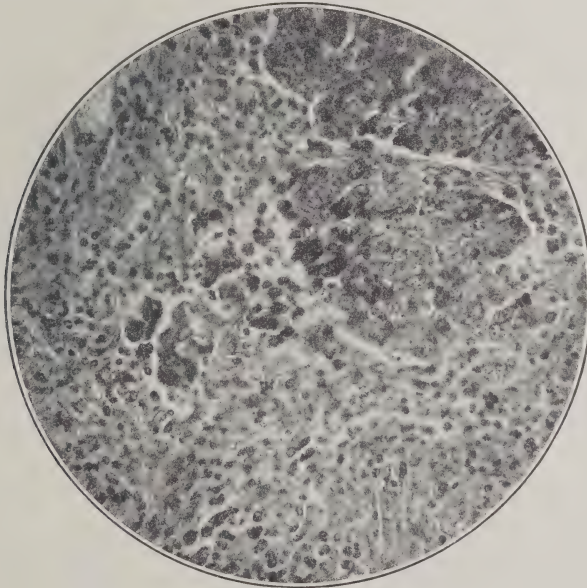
Microphotograph. $\times 260$. Epithelium at Margin of Tumor Undergoing Retrogression from x-ray Treatment.
